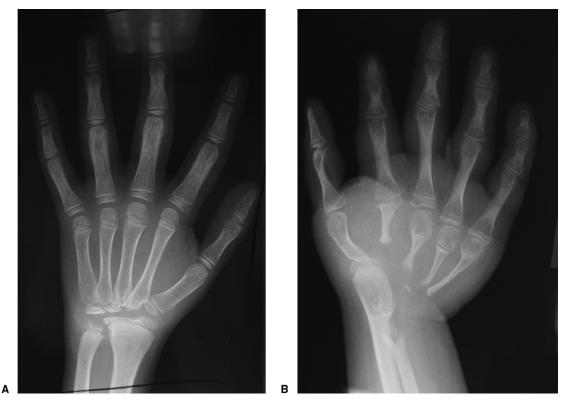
Mild and more severe appearance of the wrist on posteroanterior radiographs. A Unlisted patient; B patient 7.
